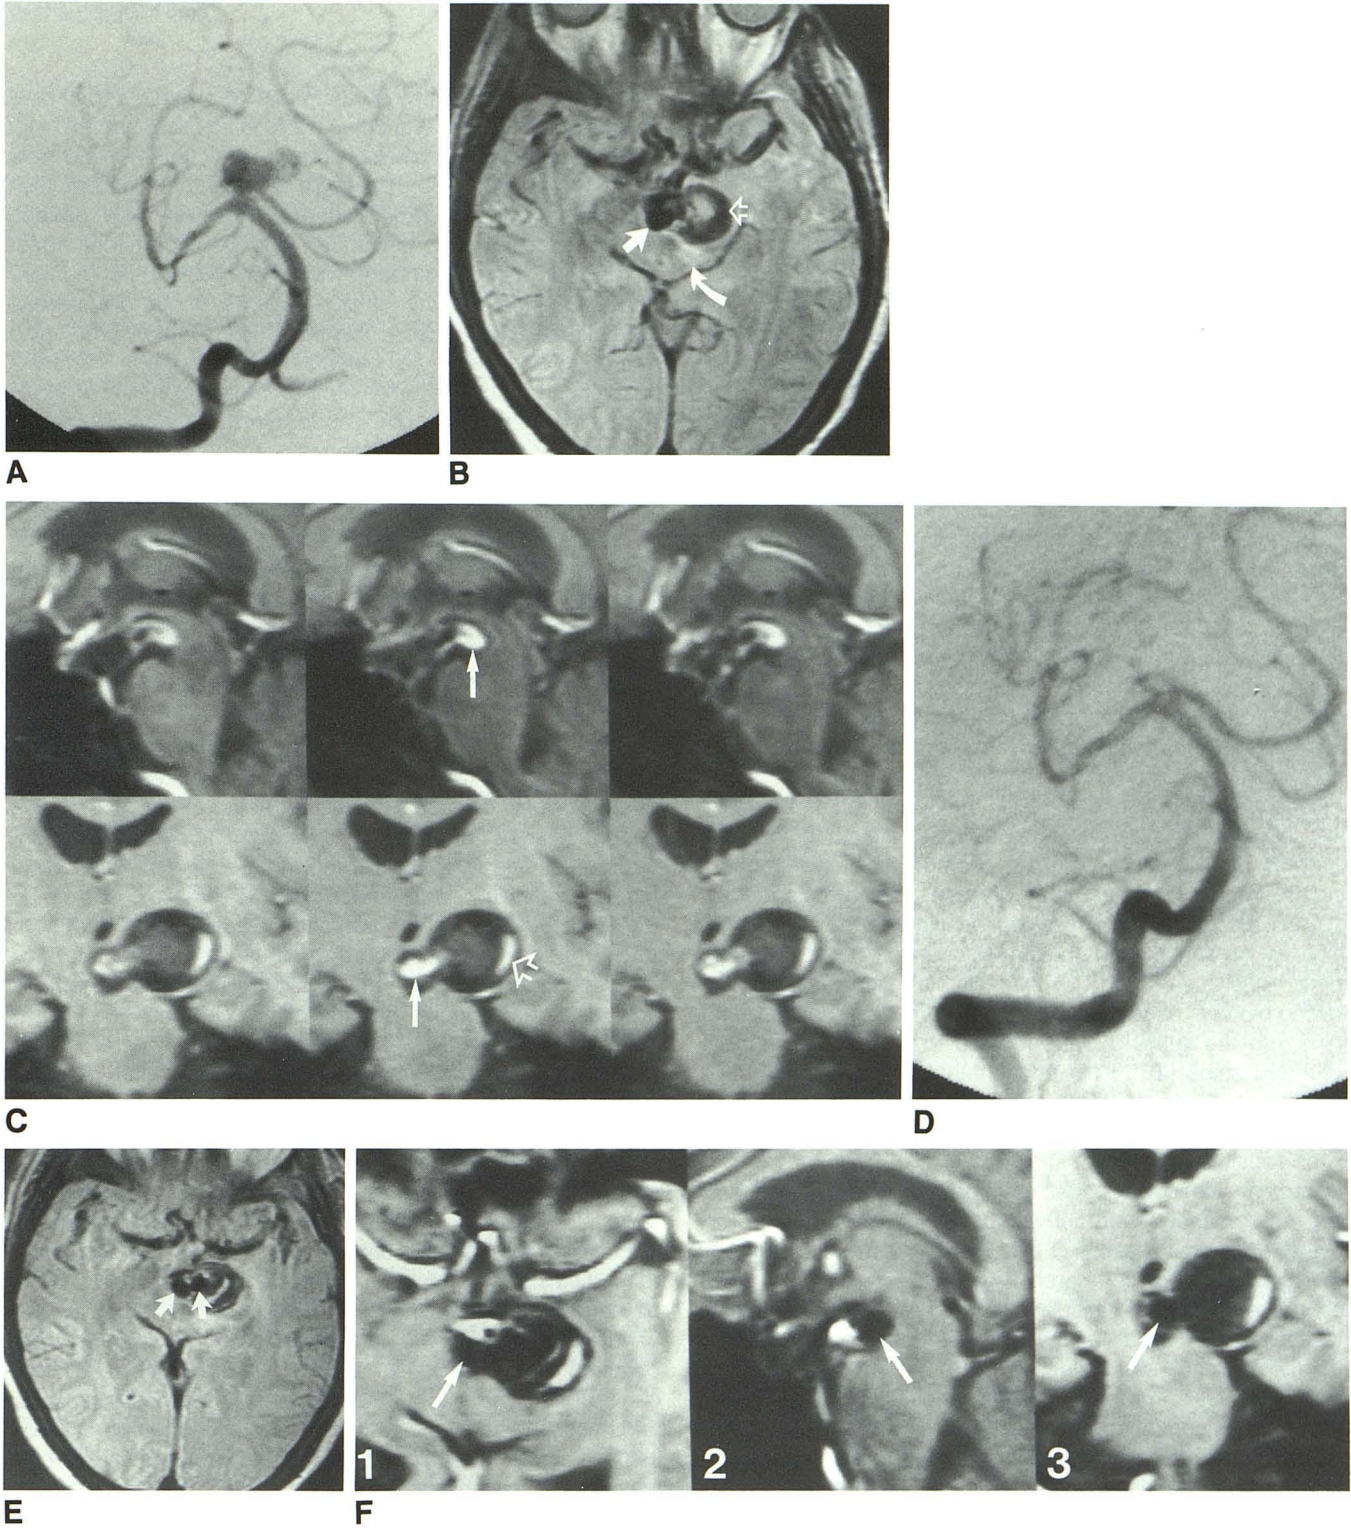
61-year-old woman with 3.0-cm partially thrombosed aneurysm of basilar tip pre- (A–C) and post- (D–F) intraaneurysmal balloon embolization. A, Right vertebral arteriogram in Towne projection demonstrates filling of irregular basilar tip aneurysm. B, T2-weighted axial MR image (SE 2000/35). Flow void is seen within patent lumen (*straight arrow*) with eccentric, mixed-signal-intensity thrombus (*open arrow*). Minimal adjacent high-intensity edema is present (*curved arrow*). C, Cine MR images in sagittal (*top row*) and coronal (*bottom row*) planes. The first column corresponds to early systole, the second column to late systole, and the third column to diastole. High signal within patent lumen (*closed arrows*) is seen. Variability of signal intensity is present depending on phase of cardiac cycle and extent of turbulence. The majority of thrombus has low intensity compared with surrounding brain; however, a peripheral zone of high signal (*open arrow*) can be seen of similar intensity to flowing blood. This zone did not opacify on arteriography, remained unchanged during the cardiac cycle, and presumably represents a methemoglobin rim within thrombus. D, After intraaneurysmal balloon embolization, repeat right vertebral arteriogram reveals complete occlusion of lumen of aneurysm. E, T2-weighted axial MR image (SE 2000/35). Two HEMA-filled balloons (*arrows*) of low signal intensity are identified. Because HEMA-filled balloons and flowing blood may have identical signal void, routine MR is not able to distinguish between these two entities. F, Repeat diastolic cine MR in axial (image 1), sagittal (image 2), and coronal (image 3) planes. Low intensity can be seen within HEMA-filled balloons (*arrows*), which is readily distinguished from high signal within patent distal basilar artery.
